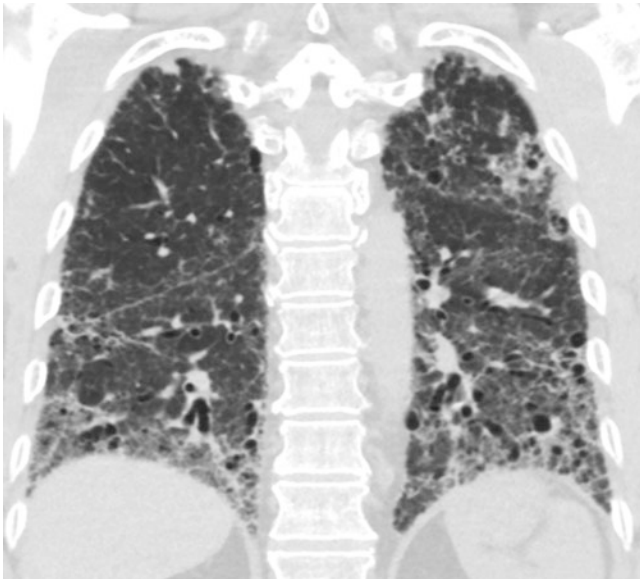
HRCT showing peripheral greater than central, and lower greater than upper lobe thickened inter- and intralobular septa with subpleural reticulation, coarse ground-glass opacity, traction bronchiectasis and bronchiolectasis, and small cystic spaces/honeycombing changes
